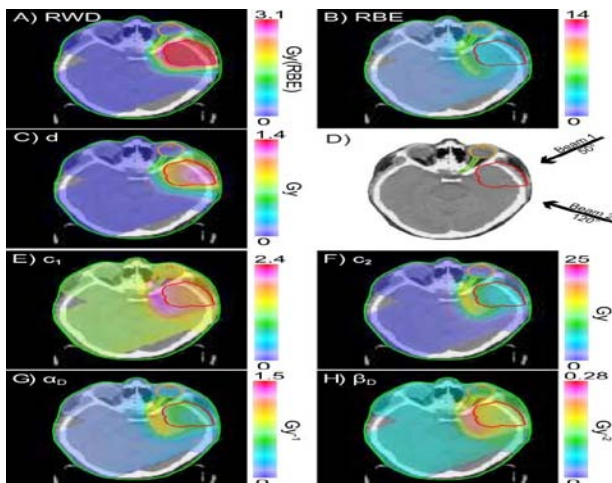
Axial CT slice of a treatment plan using the RMF model. The astrocytoma plan with two carbon ion fields was
